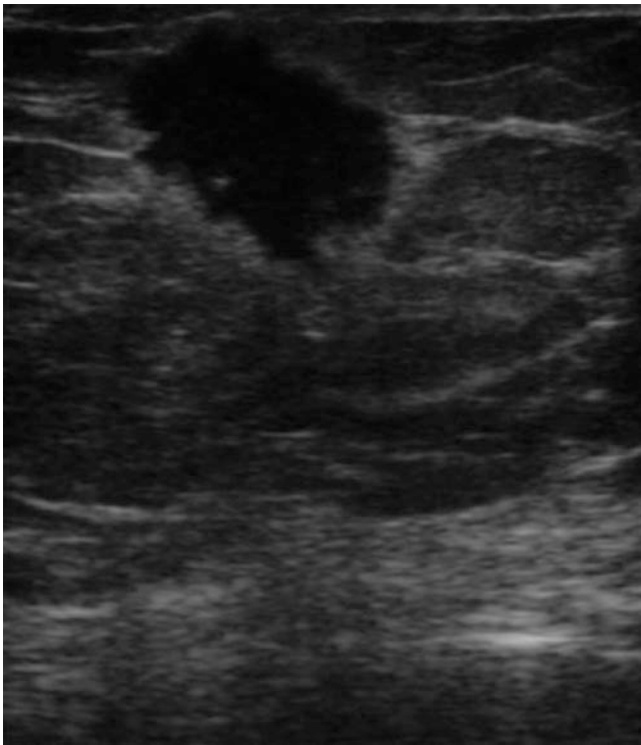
Ultrasonographic imaging of a 65-year-old male patient with a malignant mass on his right breast
